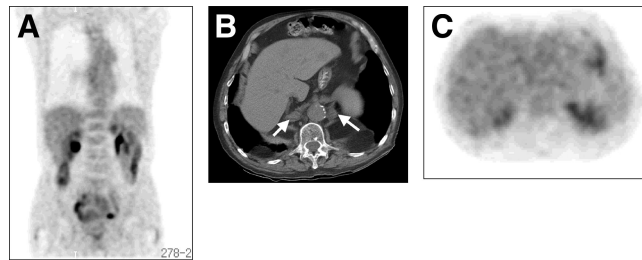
(A) ^{18}F -FDG PET scan shows no uptake in the region of either adrenal. (B) CT scan shows soft-tissue masses in both adrenal glands (arrows). (C) ^{18}F -FDG PET axial view at same level as for CT shows no abnormal uptake in the region of either adrenal.
